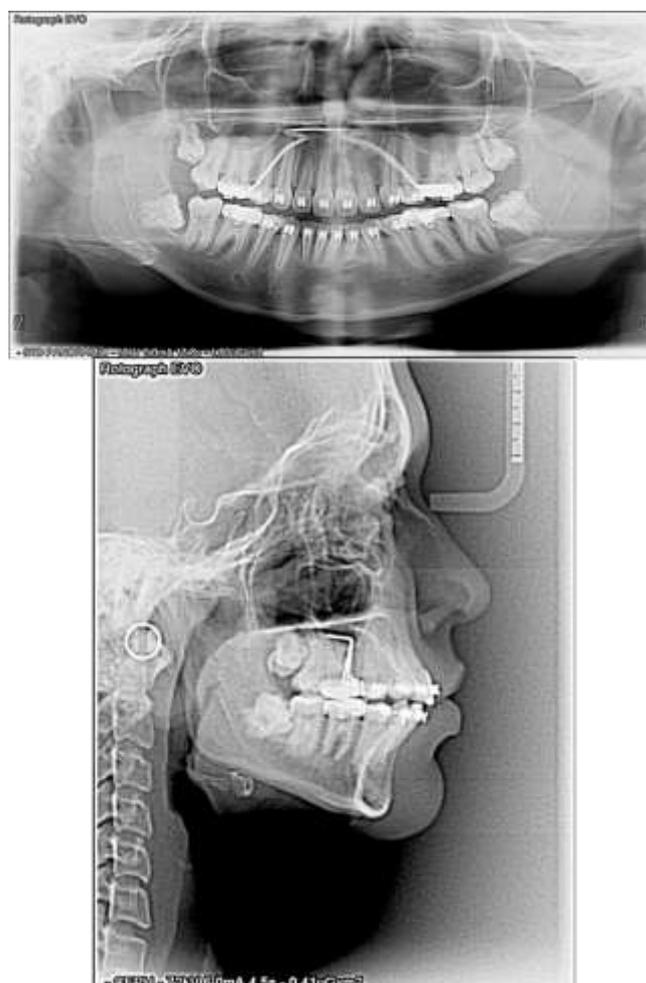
Post treatment orthopantomogram and Lateral Cephalogram
